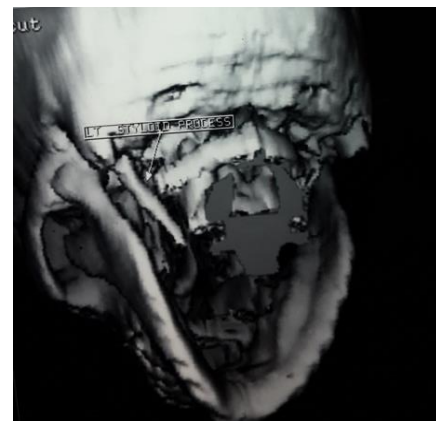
3 D - CT scan with reconstruction.
